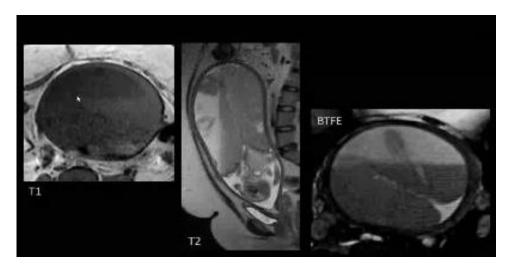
MRI - Axial and Sagital Views of Placenta
